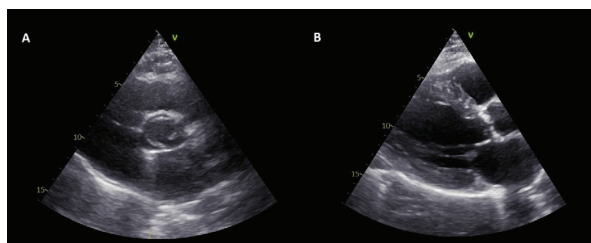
A: Parasternal short axis aortic valve view, B: Parasternal long axis aortic valve view
